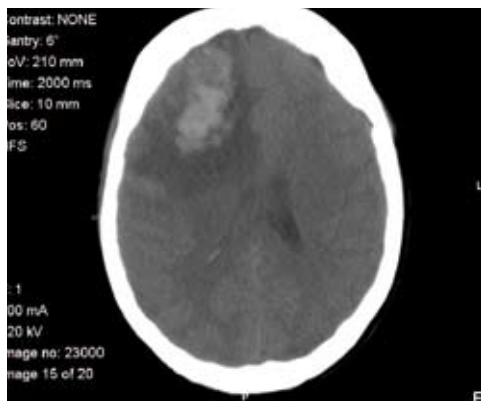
Cerebral - CT showing heterogenous lesions in a cortical-subcortical localization.
